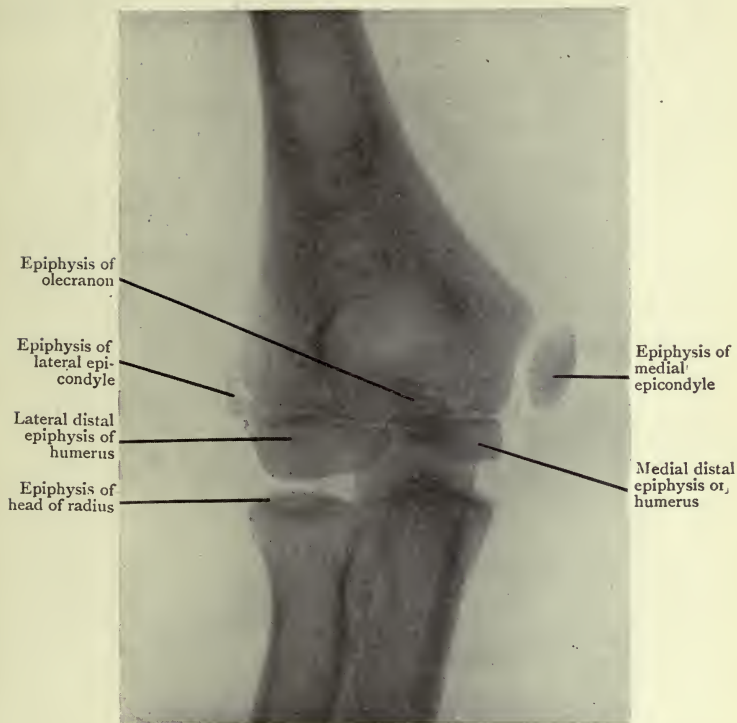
Antero-posterior Radiograph of young Elbow Joint, showing all Epiphyses.
